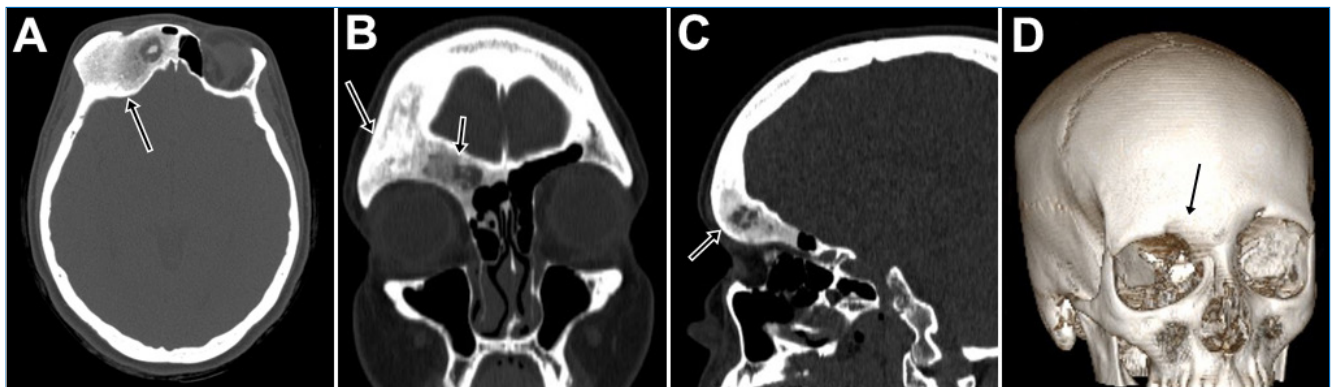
Preoperative computerized tomography (CT) scan images of the skull and face. (A) Axial cut; (B) Coronal cut; (C) Sagittal cut; (D) 3D reconstruction. The arrows point to the bone lesion in the right frontal bone area, causing the thickening and heterogeneity of the region's medullary bone and showing a “ground glass” appearance, extending to the orbital roof and the right frontal sinus.
